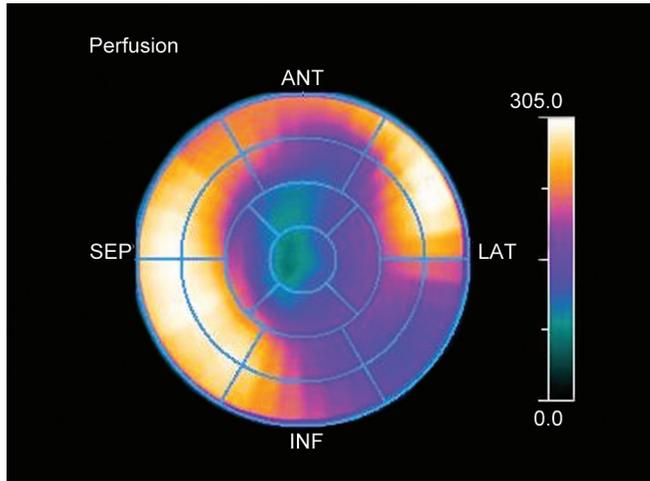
NTG SPECT depiction of significant viable myocardium in LAD territory
